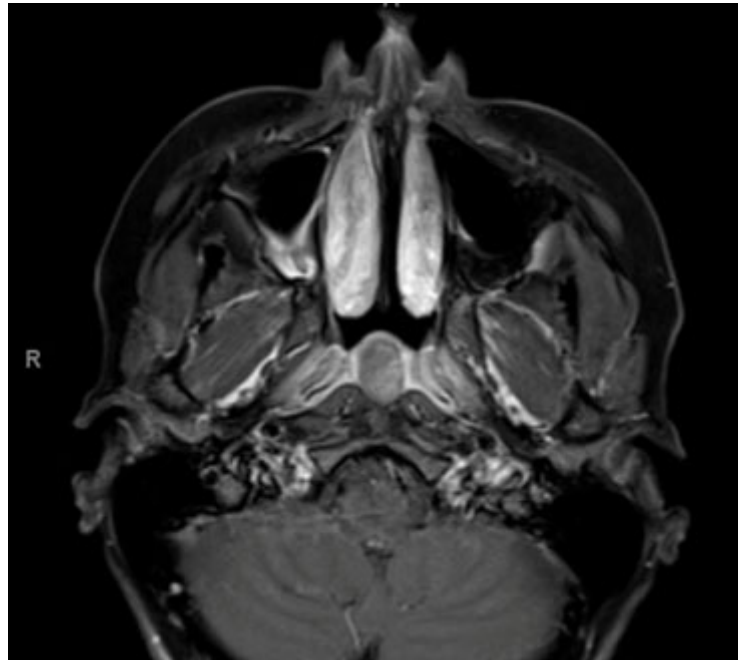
Axial T1-weighted post-contrast MRI. White arrow: Heterogeneously-enhancing mass in the nasopharyngeal soft tissues. Note mild enhancement of surrounding mucosa
